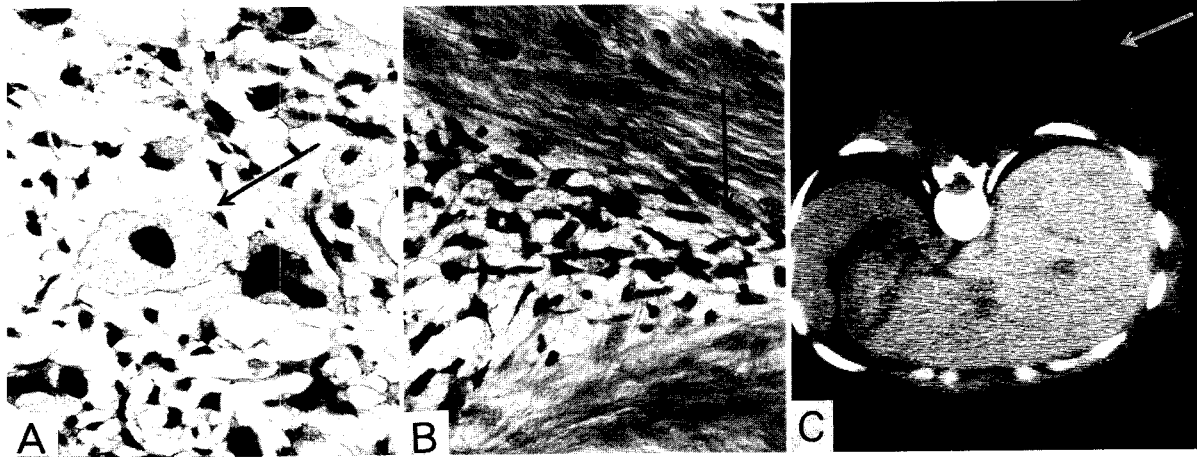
Case 2. A: Pleomorphic liposarcoma consisting almost entirely of bizarre lipoblasts with hyperchromatic nuclei and numerous lipid droplets in the cytoplasm (arrow) (H. E., $\times 200$). B: Invasion of tumor cells into muscles (arrow) (H. E., $\times 200$). C: Computed tomography of the second malignant neoplasm (liposarcoma) on the back (arrow).
